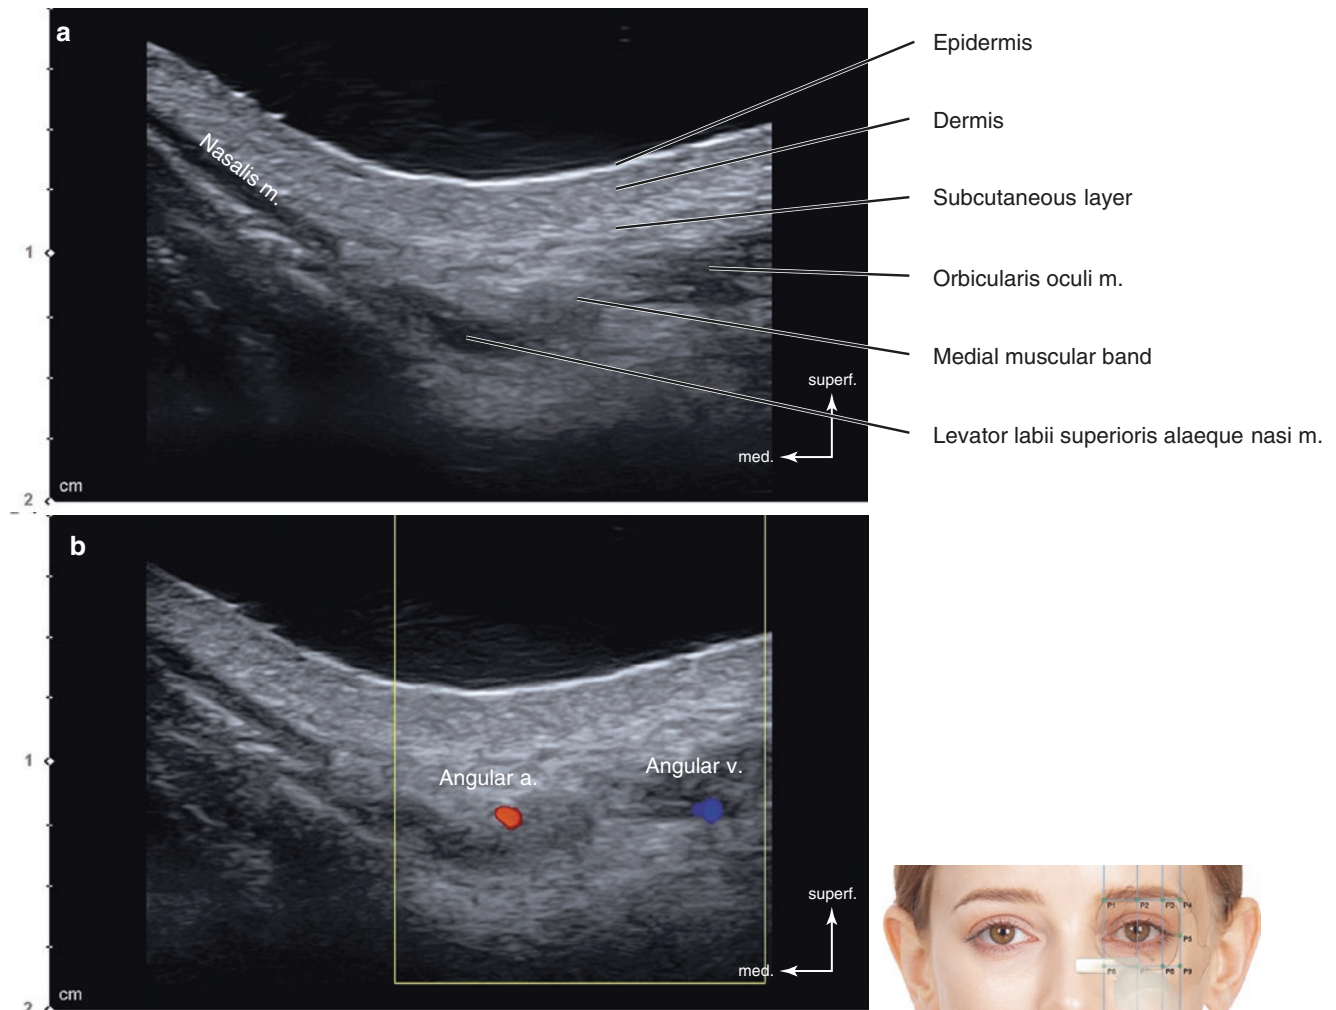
Ultrasonography on the intersection point of TL3 and PL1 (P6). (a) B mode (transverse view, 15 MHz by linear transducer), (b) Doppler mode (transverse view, 15 MHz by linear transducer), (c) B
